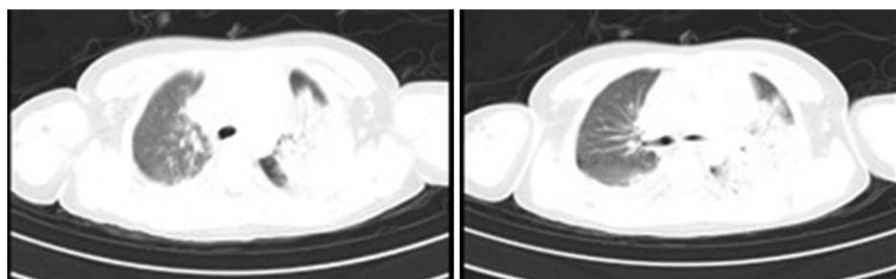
CT scan of chest at admission. Left lobe pneumonia and mild pleural effusion were found. CT = computed tomography.
